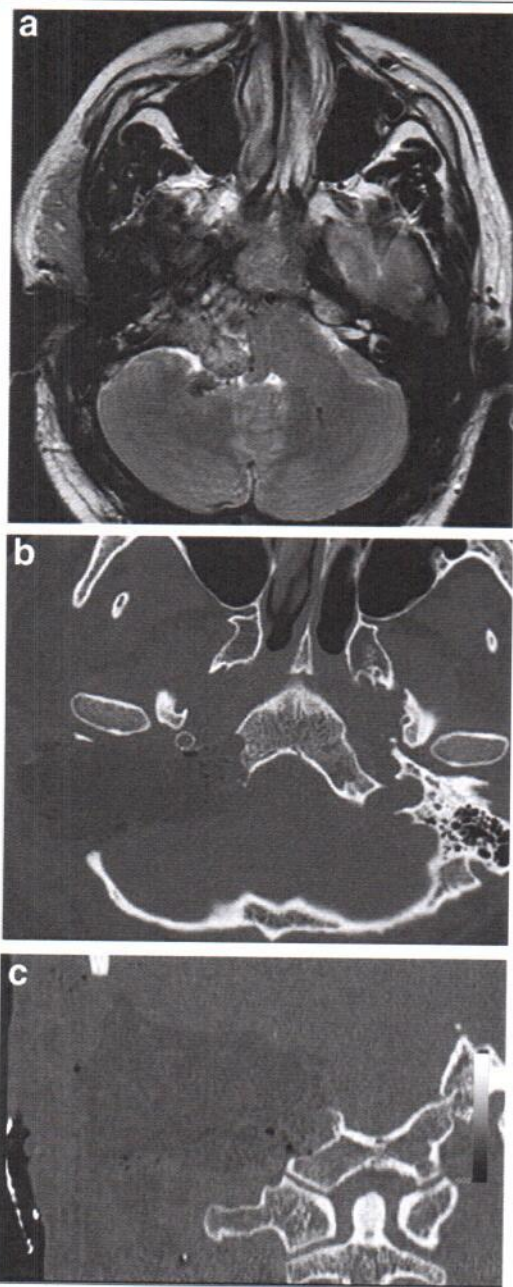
(A) Preoperative MRI showing a right-sided type C3D12 tympanojugular paraganglioma. (B) Postoperative axial and (C) coronal high-resolution CT scans of the same case managed with infratemporal fossa type A approach (IFTA-A) with transcondylar-transtubercular extension. Notice the extent of bone removal at the level of the occipital condyle and the meshes of the stent inside the internal carotid artery
